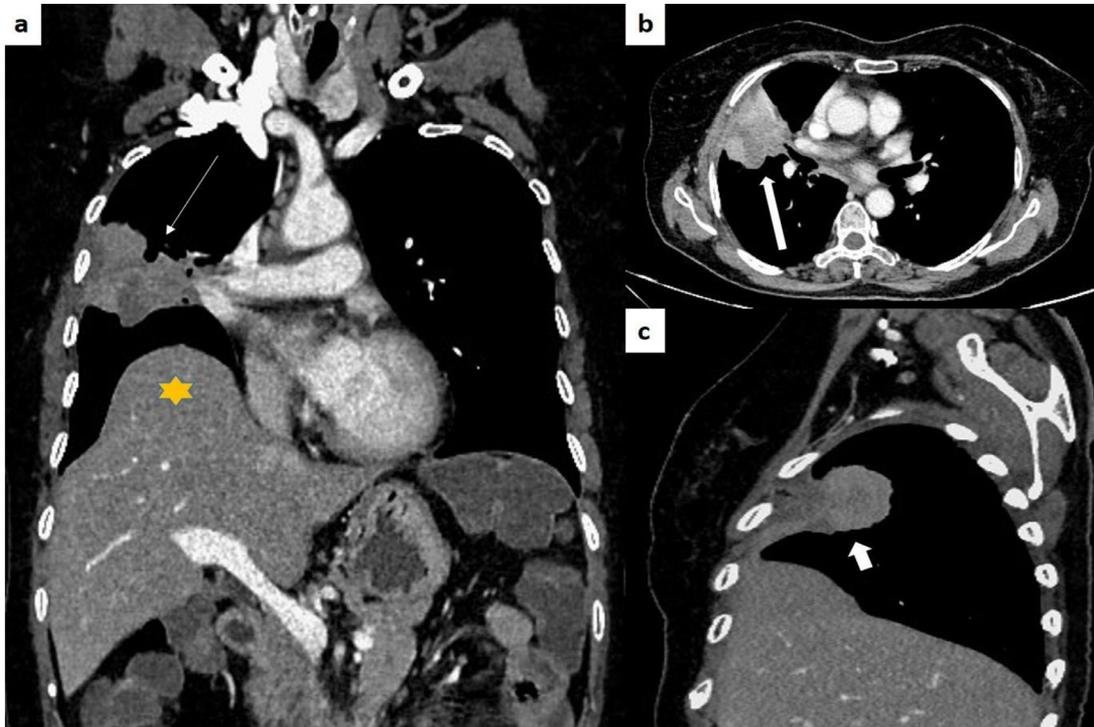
Primary monophasic synovial sarcoma of lung, contrast enhanced CT: (A) coronal image showing an irregular heterogeneously enhancing mass in right lung, abutting right hilum and involving the adjacent costal pleura (white arrows) with focal eventration (yellow asterisk).
